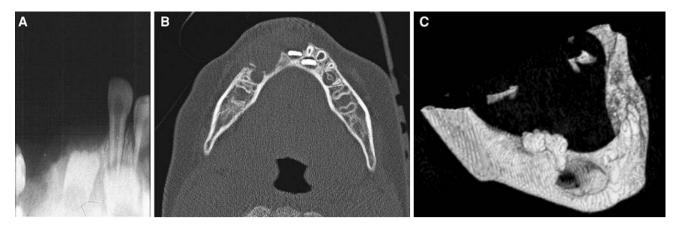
(a) Periapical X-ray from the third recurrence, (b) axial view, and (c) 3D-CT scan reconstruction
